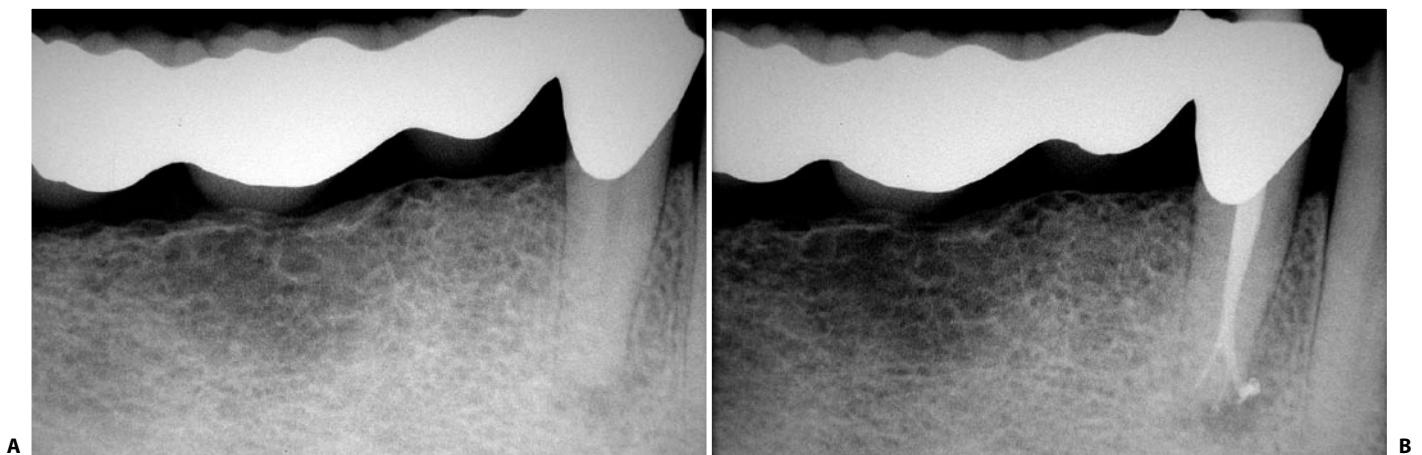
A. Preoperative radiograph of the lower right first premolar: the tooth needs a root canal treatment. B. Postoperative radiograph. The irrigating solutions need time to completely perform their activity. Only then the treatment, shaping, cleaning, and obturation, will really be three-dimensional.
